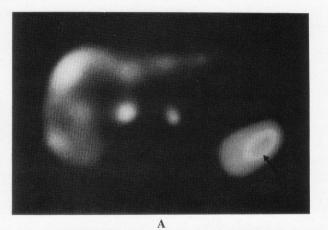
Planar ^{99m}Tc-DTPA-HSA scintigraphy showed tracer uptake in the spleen (arrow) (Posterior view, H: heart, L: liver).
